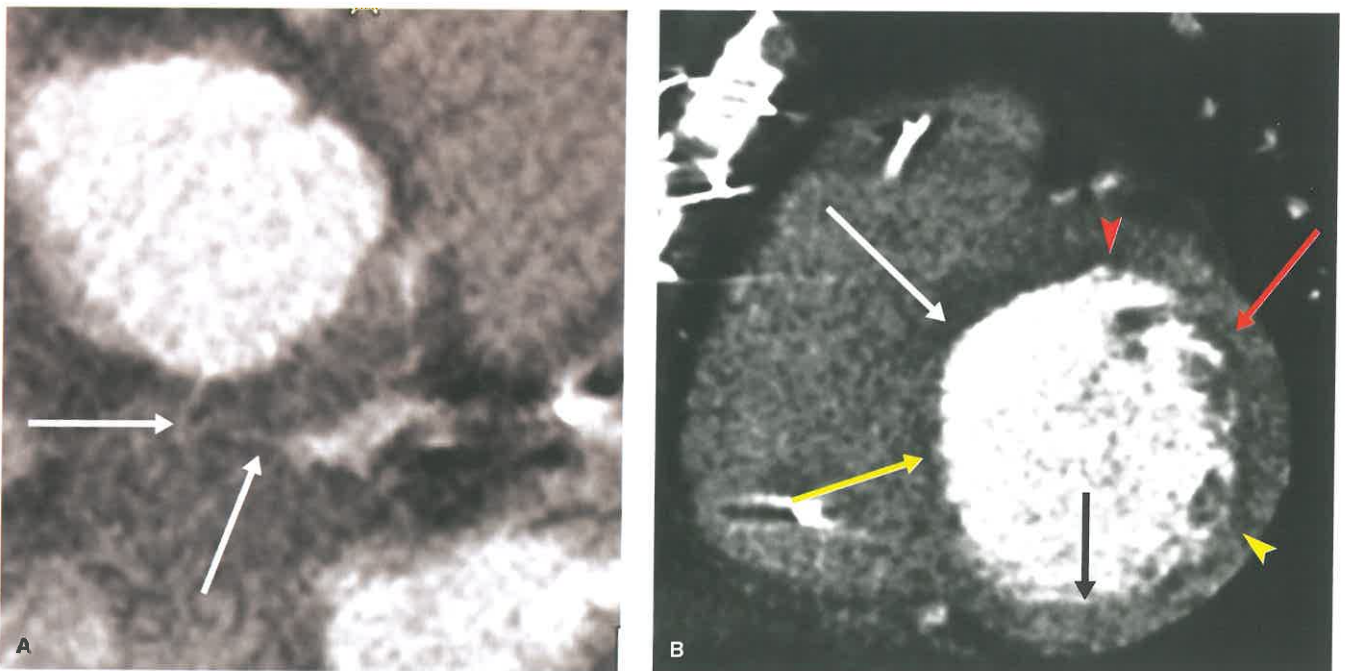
Left Main Coronary Artery Territory Myocardial Infarct in a 60-Year-Old Man in Disseminated Intravascular Coagulation (DIC), Platelet Count of 2,950/mL, Troponin I of 57.7 ng/mL, and a Heart Rate of 122 bpm. A: Axial oblique image from a retrospectively gated coronary CTA shows near-complete occlusion of the LM (*white arrows*). B: Short-axis image through the base shows subendocardial hypoperfusion involving the anteroseptal (*white arrow*), anterior (*red arrowhead*), anterolateral (*red arrow*), and portions of the inferolateral (*yellow arrowhead*) and inferoseptal (*yellow arrow*) segments. These findings are consistent with infarcts in both the LAD and LCx distributions. The inferior segment (*black arrow*) and portion of the inferolateral and inferoseptal segment are supplied by the RCA which was normal.
